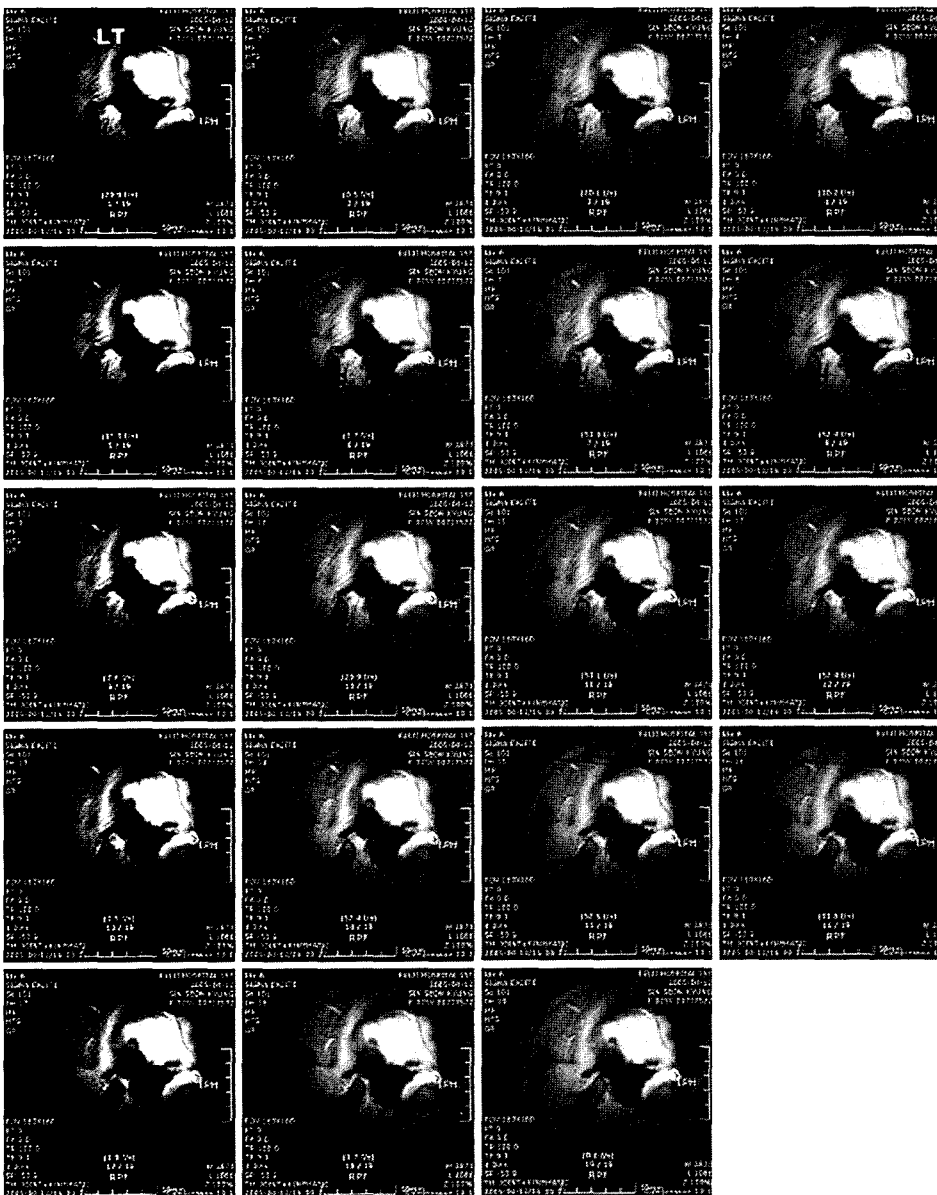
The pseudo-dynamic MRI of TMJ ID with reduction.
